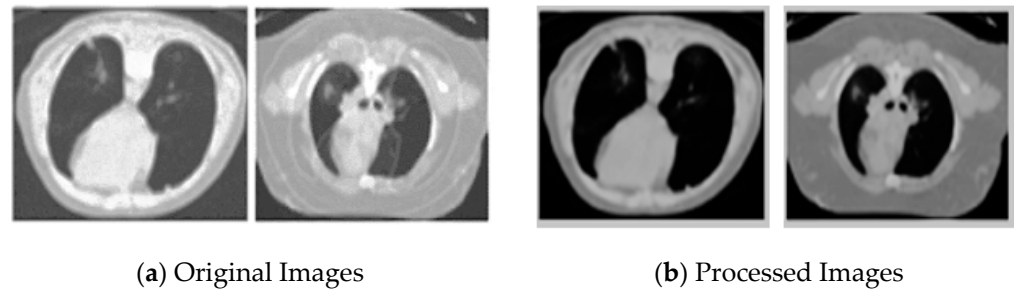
Shows unprocessed (original images) and processed lung CT scans.
